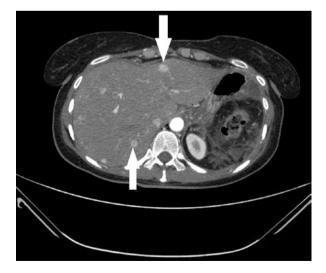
Multidetector computed tomography axial section demonstrating hypervascular NF-bilobar liver metastases from PanNET (marked by white arrows)
